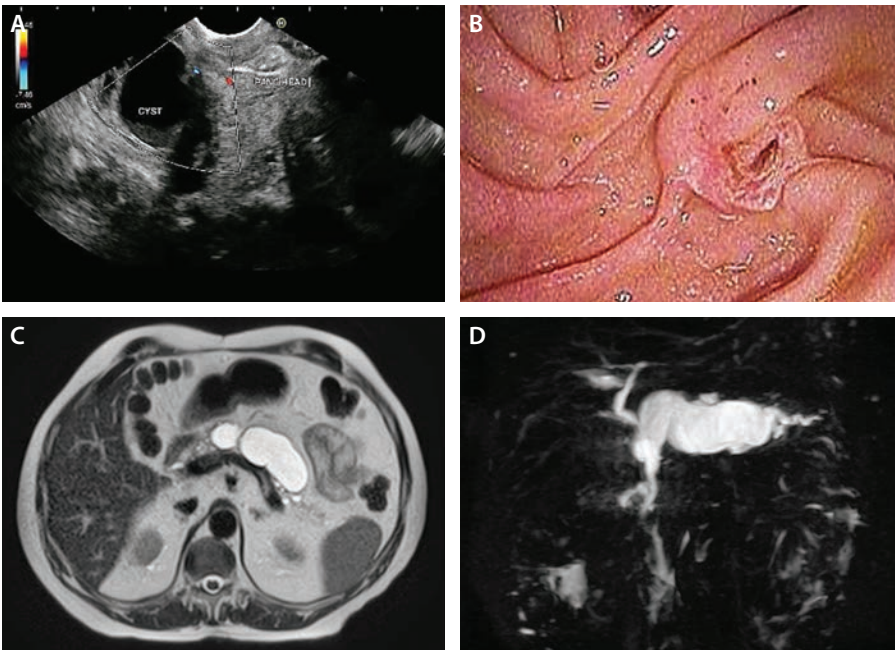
Intraductal papillary mucinous neoplasm. Endoscopic ultrasound shows a unilocular cystic lesion with associated duct dilation (a). Endoscopy shows a “fish mouth” ampulla (b). Magnetic resonance imaging shows segmental dilation of the main pancreatic duct in a “sausage”-like shape (c), and magnetic resonance cholangiopancreatography shows marked dilation of the main pancreatic duct along almost the entire length of pancreas (d).
